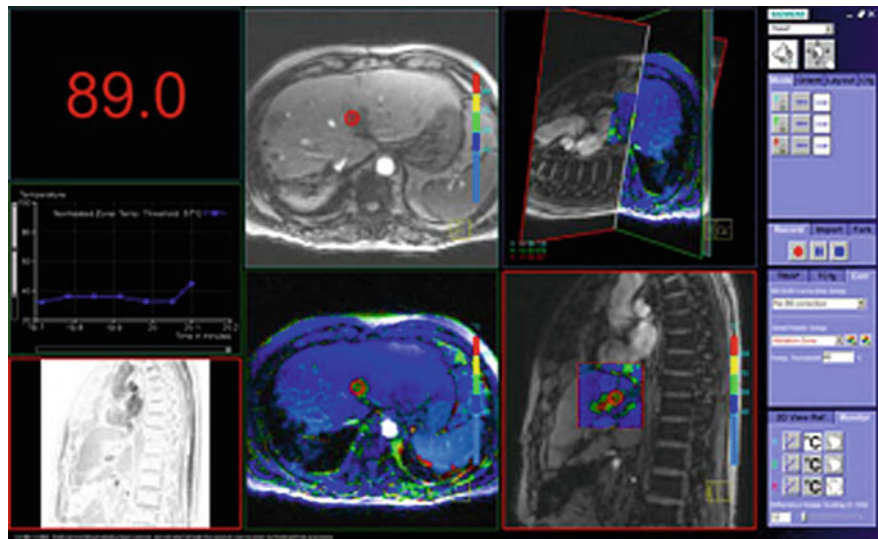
Interactive Front End (Siemens) user interface for MRI-guided thermal monitoring of a liver procedure. Various planes, with both grayscale and temperature monitoring views, are provided to guide the procedure. (Courtesy of Christine H. Lorenz, Siemens Corporate Research, Baltimore, MD, USA)
